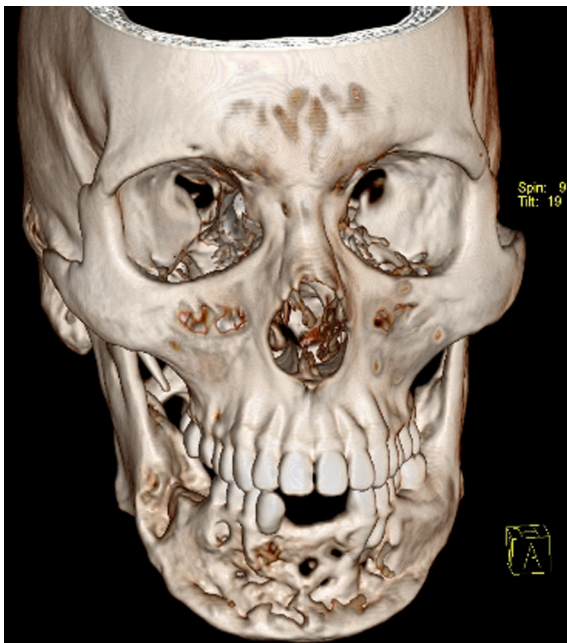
Post-op 6 months 3D CT.
